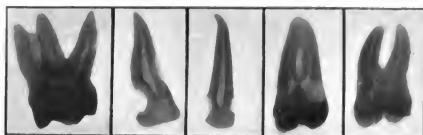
Radiographs of receded pulps, and constricted chambers, as found in advanced age.
